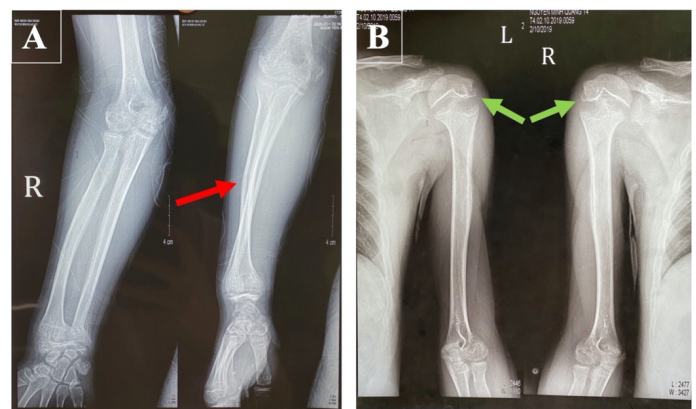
Radiograph of the left forearm (A) and arms bilateral (B) shows diffuse demineralization of bones, fatigue fracture (looser zones) of diaphysis in left radius (red arrow), widening of bilateral proximal humeral physics (green arrows)
